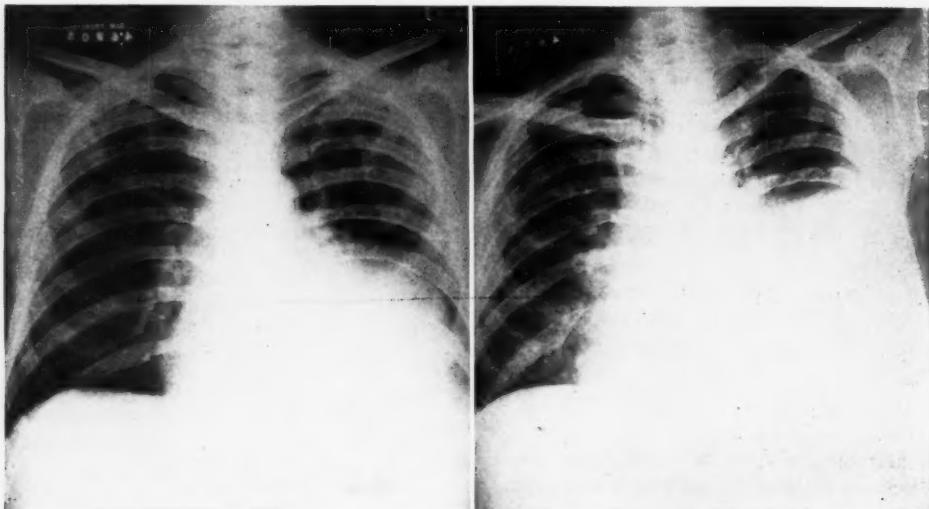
(Left) Roentgenogram of chest made July 7, 1947, showing a marked increase in prominence of the left border of the heart, with the outline now sharply defined.
